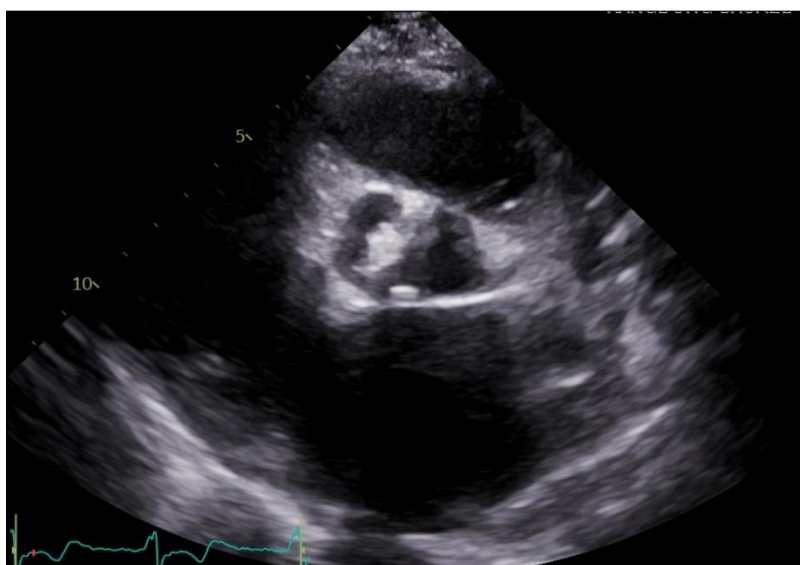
Preoperative Transthoracic echocardiography (TTE) showing a bicuspid aortic valve (BAV) at parasternal short axis view
